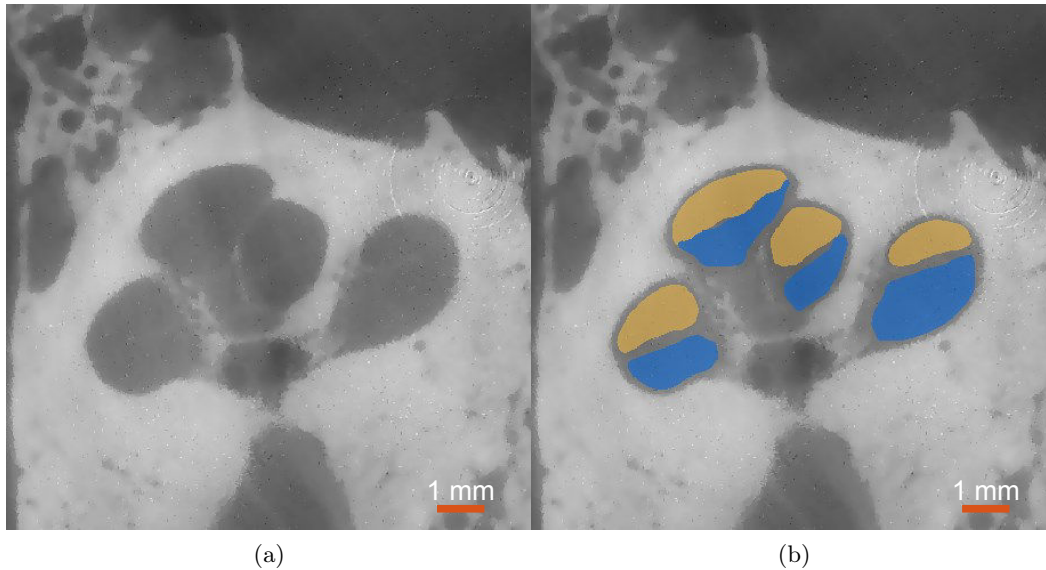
(a) μ CT image acquired on patient #4. An anisotropic diffusion filter was applied to reduce image noise. (b) Segmentations of the scala tympani (blue) and the scala vestibuli (yellow). The round window is not present in this slice.
